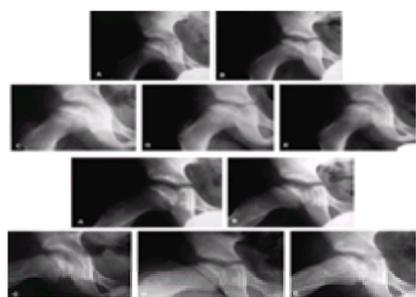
Anteroposterior (top) and lateral (bottom) views of a 7-year-old boy who presented with hip pain and a limp. A: At presentation, the patient was in the initial radiographic stage of the disease; his prognosis was indeterminate. B: Six months after presentation, he had minimal loss of height of the lateral pillar and some radiolucency in that region, as well as significant bone resorption centrally. Note how the lateral pillar maintains its height throughout the course of the disease. C to E: One year (C), 18 months (D), and 3 years (E) after onset of disease. The patient had only mild symptoms on occasion, and maintained good range of motion throughout the disease course. Only symptomatic treatment was provided.
